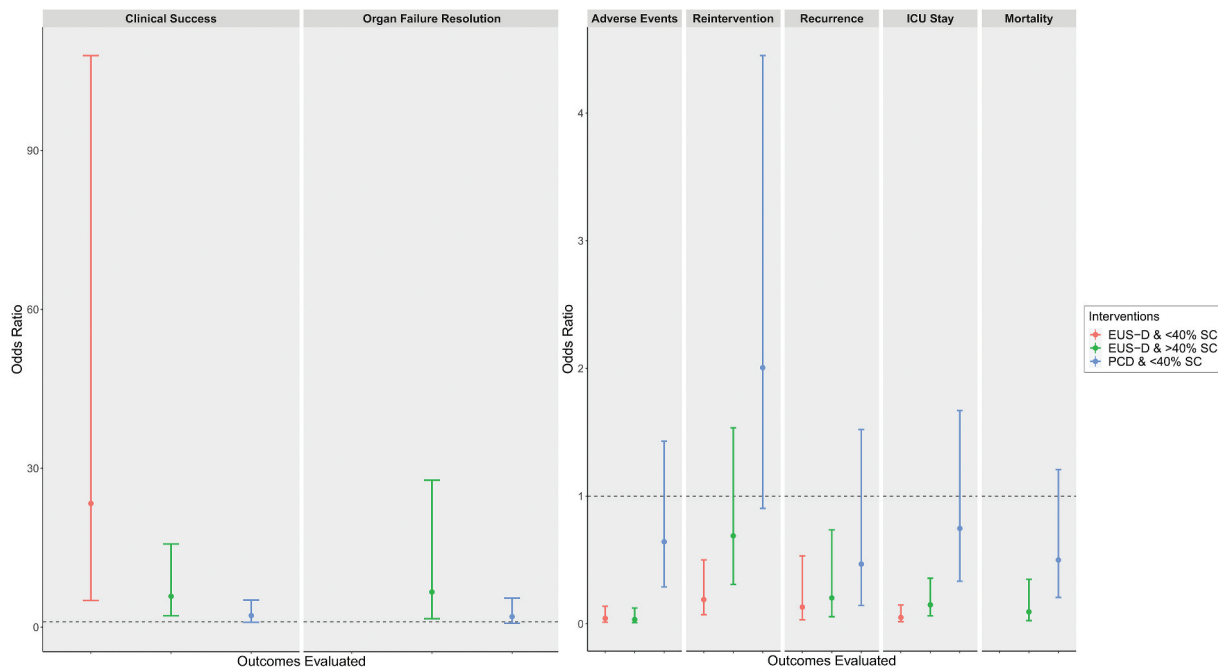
Forest plot of the adjusted Odds ratio for the various outcome parameters compared between the four groups based on modality of drainage and percentage of solid component in the walled-off-necrosis: a) comparison for clinical success and organ failure resolution; b) comparison for adverse events, reintervention, recurrence, ICU stay and mortality. (PCD with >40% solid component is taken as the reference arm). Abbreviations: ICU intensive care unit; EUS-D endoscopic ultrasound guided drainage; PCD percutaneous catheter drainage; SC solid component.
